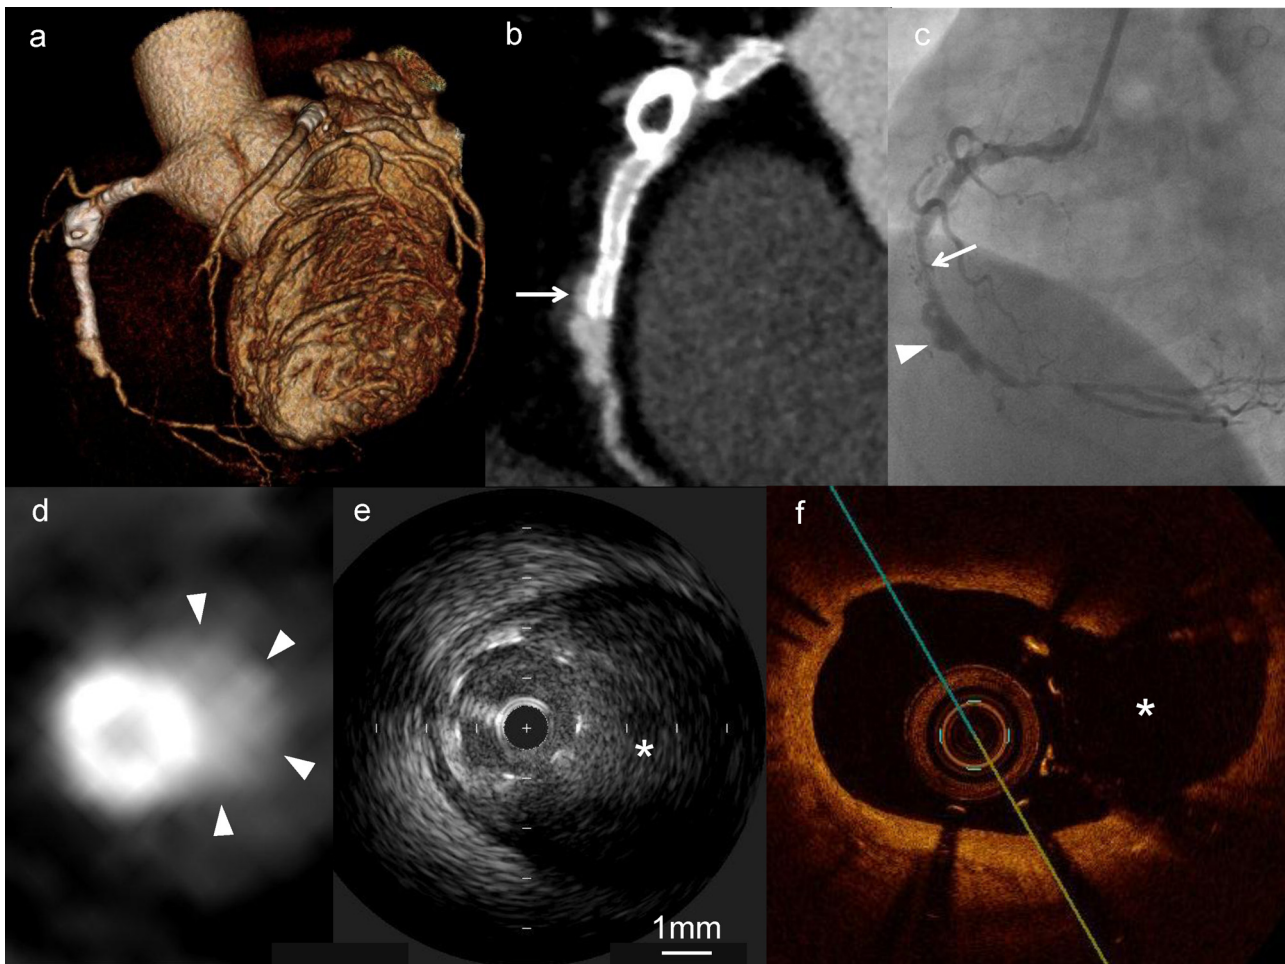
(a and b) Computed tomography coronary angiography 6 months after coronary angioplasty revealed positive remodeling of the coronary artery around the distal zotarolimus-eluting stents (ZES). (c) Follow-up coronary angiography revealed restenosis in the ZES implanted in the right coronary artery (arrow) and marked coronary aneurysm formation around the distal ZES (arrow head). (d) Multi-planar reconstruction cross sectional image at site of arrow in (b) showed the late acquired stent malapposition (arrow heads). (e and f) Intravascular ultrasound and optical coherence tomography at the site of the arrow head in (c) showed marked vessel remodeling and malapposition (*).
